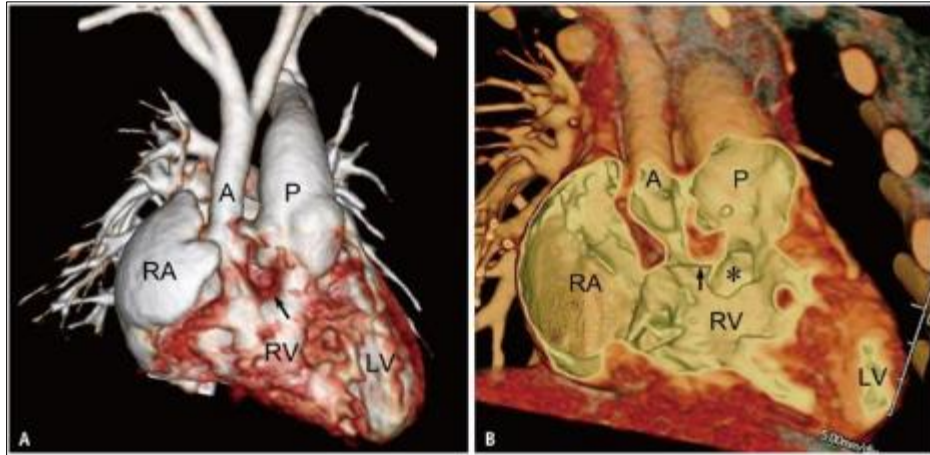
Double outlet RV with subpulmonary VSD in a neonate. A, B. Standard (A) and transparent-lumen (B) volume-rendered CT images show that both great arteries are connected to the morphologic RV. The outlet septum (arrows) is fused with the posterior margin of the subpulmonary VSD (asterisk). A is relatively small, and subaortic stenosis is observed. In addition, coarctation of the aorta was observed in this patient (not shown). A = ascending aorta, LV = left ventricle, P = pulmonary artery, RA = right atrium, RV = right ventricle, VSD = ventricular septal defect
